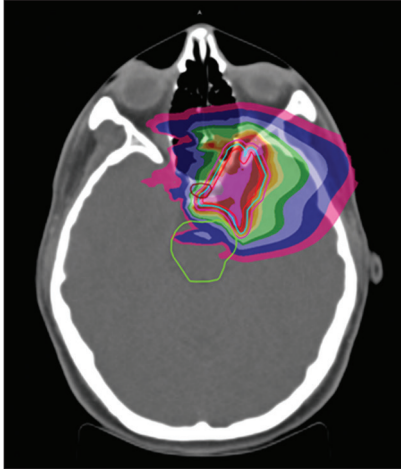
Pre-treatment magnetic resonance imaging (MRI) with therapy plan. Colours only provide a visual representation of the cited area (therapy plan).
